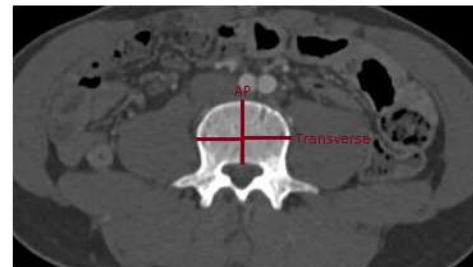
Measurement of antero-posterior and transverse diameter of vertebra: Axial CT section in bony window
